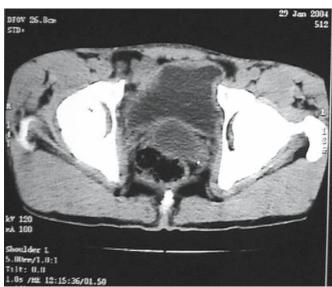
A computed tomography (CT) scan shows the left seminal vesical cyst with a Hounsfield value not suggestive of tumor
